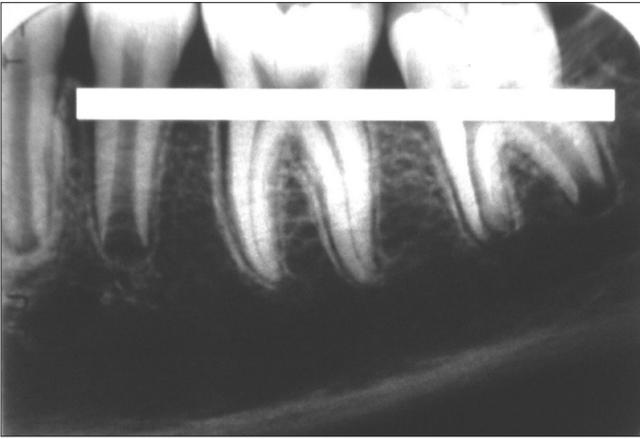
Digitized images showing a horizontal section of the roots randomly selected from the antemortem radiograph.
